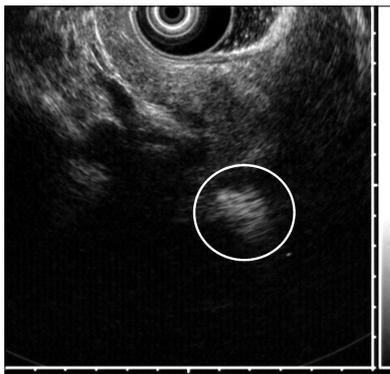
Endoscopic ultrasonography imaging of the patient. The pancreatic mass exhibited heterogeneous hyperechogenicity (circle).
